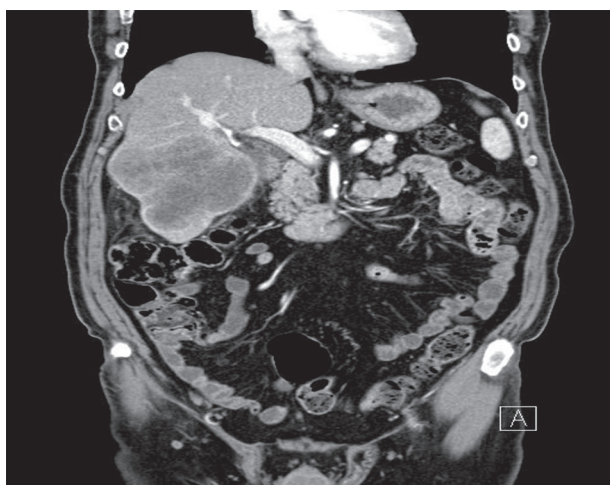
CT of suppurated metastases in IV and V segments
